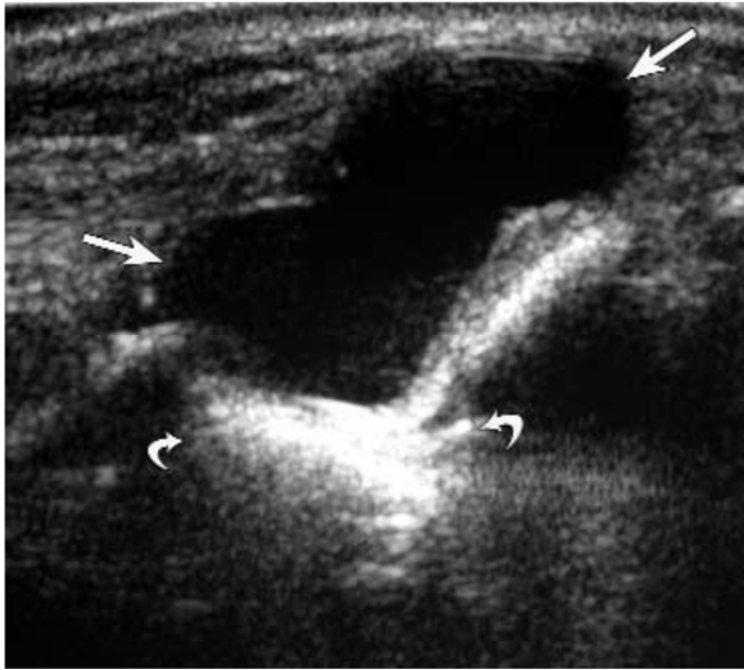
Dorsal ganglion cyst in a 32-year-old woman. Sagittal sonography shows a 30-mm anechoic ganglion cyst (arrows) with posterior acoustic enhancement (curved arrows). Note the lobular and well-defined border. (134)
